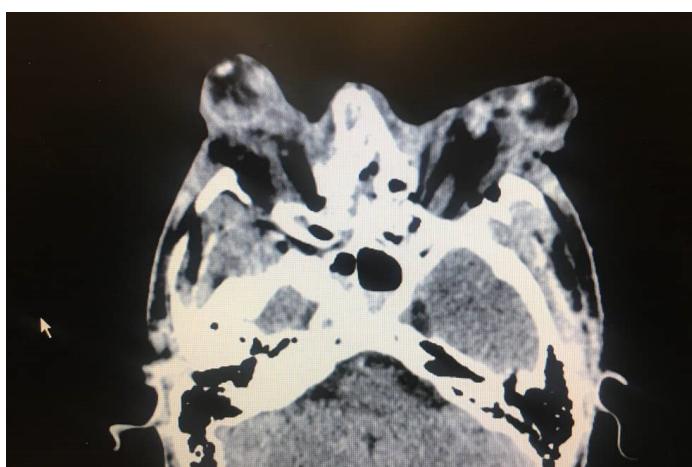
Computed tomography scan of bilateral globes dislocation
